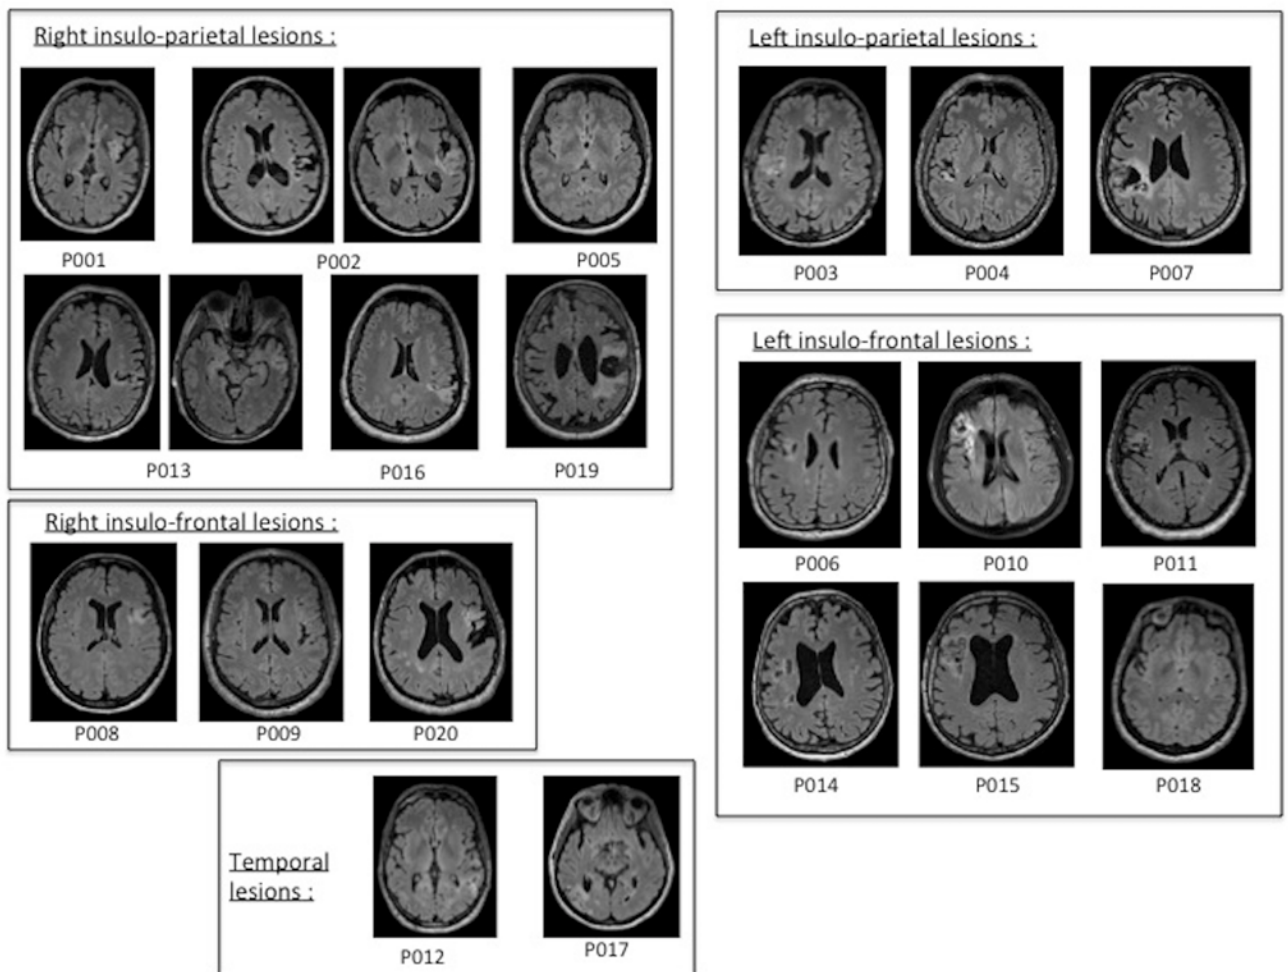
MRI of the 20 patients
